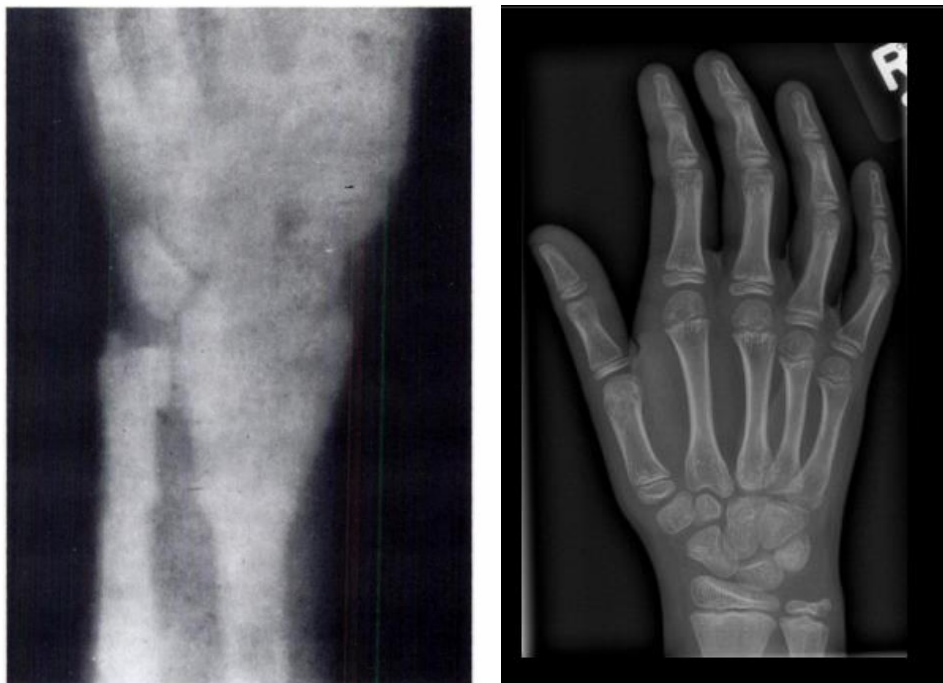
left, the first x-ray image acquired in America (23). Right, a modern x-ray image [Case courtesy of Kellie Grant, Radiopaedia.org, rID: 40336]
